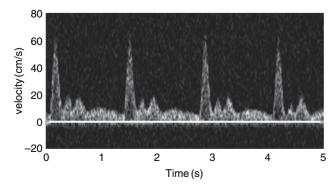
A sonogram of continuous wave Doppler and pulsed wave spectral Doppler.
